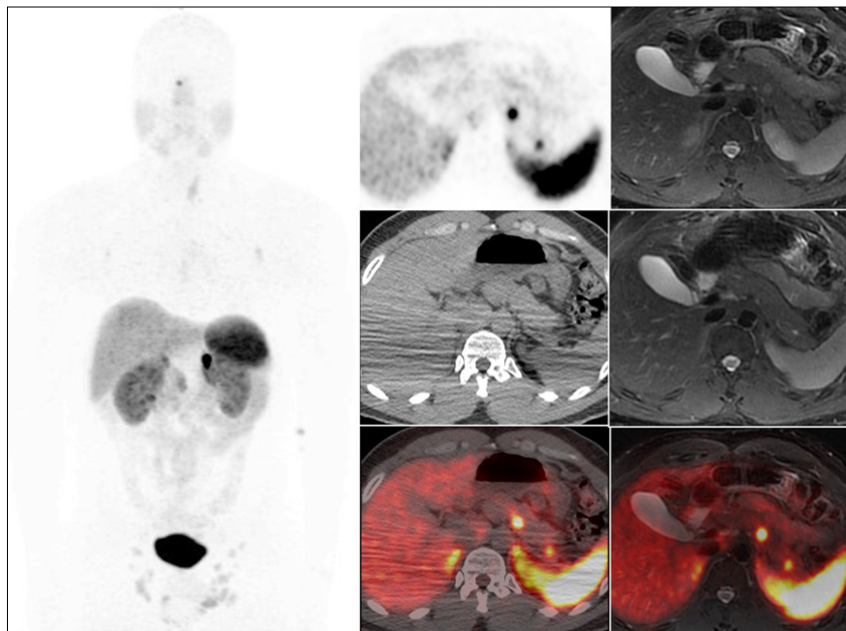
Coronal MIP PET and axial slices of T2-weighted PET/CT and PET/MRI sequences. A 35-year-old male patient with a family history of NEM1 syndrome underwent abdominal CT scan, which revealed a para-aortic nodule. He also underwent a MIBG scintigraphy yielding a negative result. A ^{68}Ga -DOTA PET scan was requested for investigation of neuroendocrine tumor. The patient had a history of thyroidectomy and pituitary hyperplasia. ^{68}Ga -DOTATATO PET/CT and PET/MR images revealed: focal areas in the body and tail of the pancreas, uncorrelated to CT images and characterized as nodules on MRI with high T2 signal and diffusion restriction. This case demonstrates the superiority compared to MRI soft tissue contrast.
